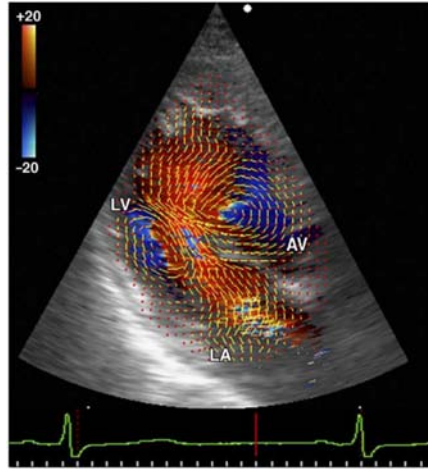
Flow velocity vector field (in yellow) superimposed on color Doppler ultrasound (adapted from [87]).
